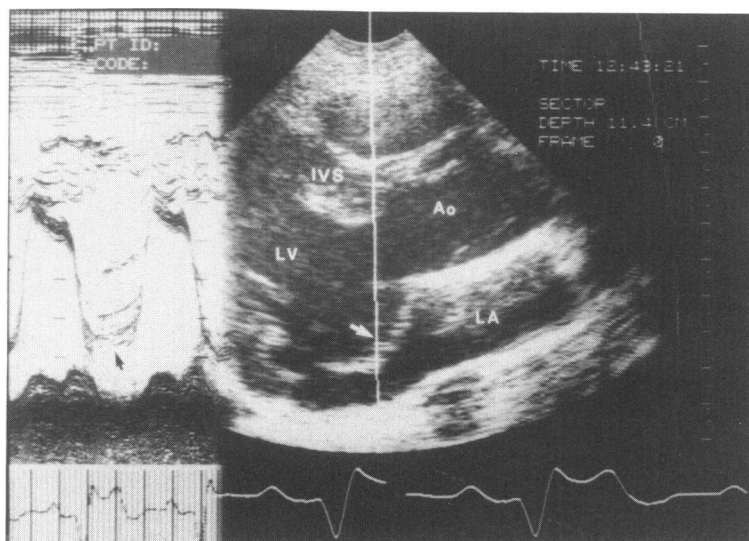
Mitral valve prolapse. The left side points to holo-systolic hammocking of the mitral valve (arrow) on the M-mode echocardiogram taken from the two-dimensional echo long axis view. The 2-D echo demonstrates hammocking of the anterior leaflet of the mitral valve (arrow).
